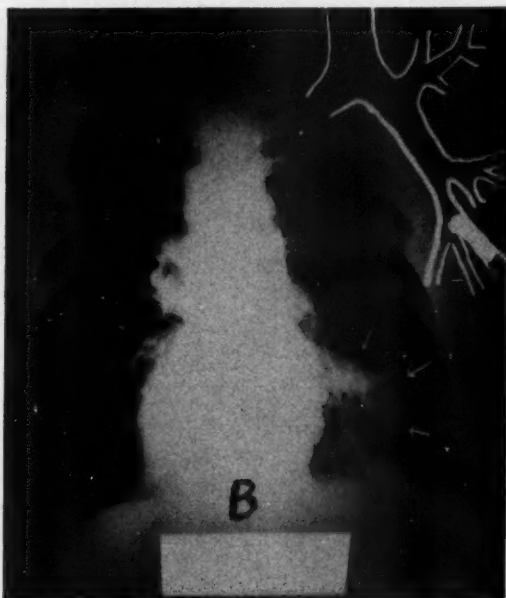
Roentgenogram of Patient "B" showing atelectasis in right base. Inset shows bronchoscopic findings of a benign papilloma.
